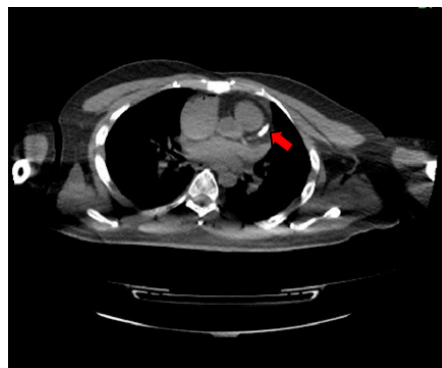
CT thorax with calcified LAD
